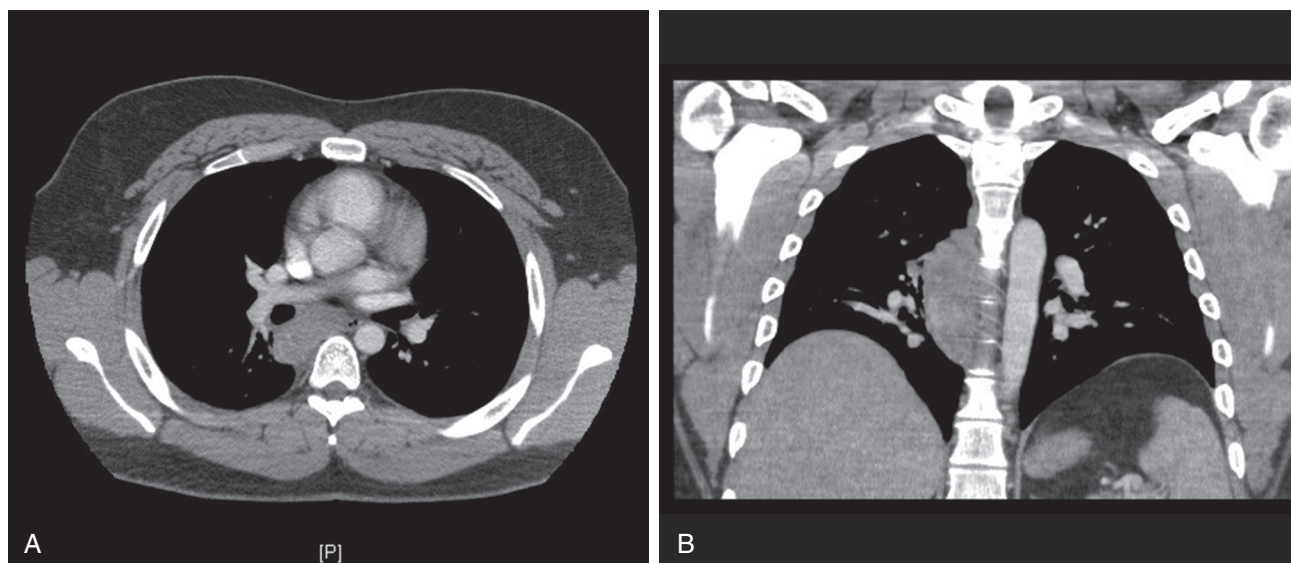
■ A, CT scan showing necrotizing granulomatous infection of the posterior mediastinum also seen in the coronal reconstruction (B).
